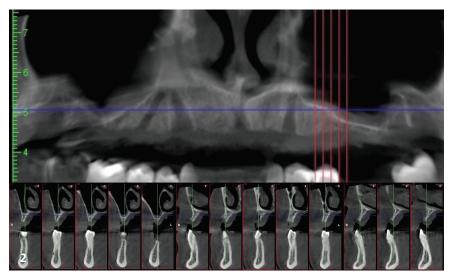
Radiograph assessment showed limited bone availability.
